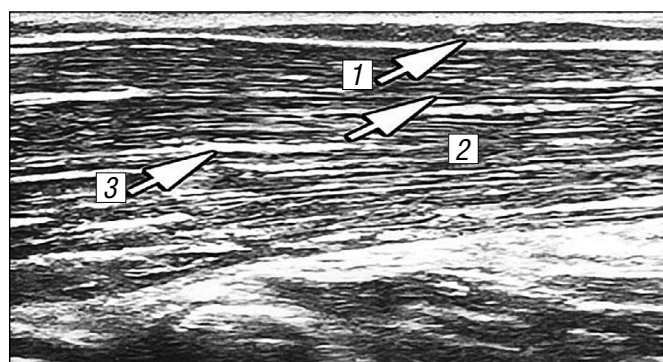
Ultrasound image of the shoulder muscle (*m. brachioradialis*) in the antero-longitudinal lateral position at the 1<sup>st</sup> stage of myofibrosis. Epimysium (1), muscle bundle (2), perimysium (3).
